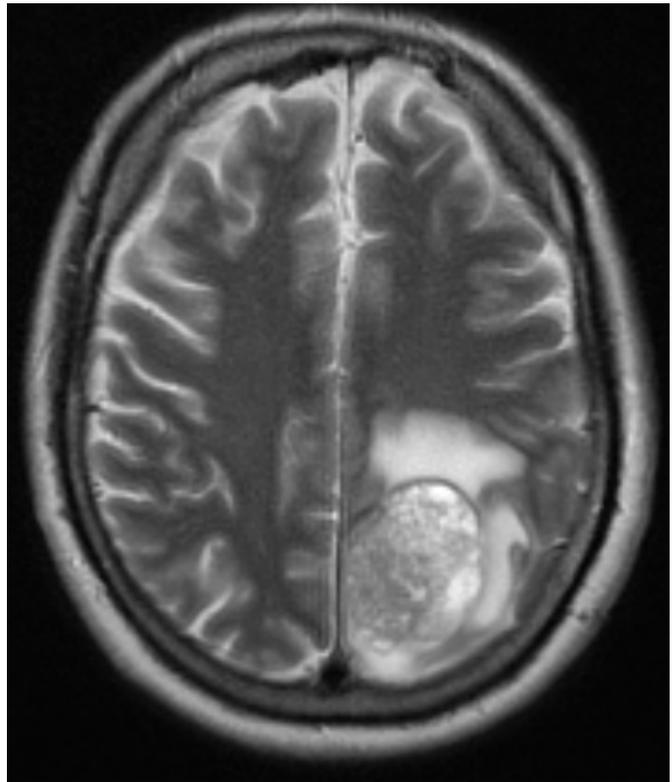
MRI of the brain without contrast showing a complex, enhancing, and hemorrhagic mass within the left parietal lobe.
